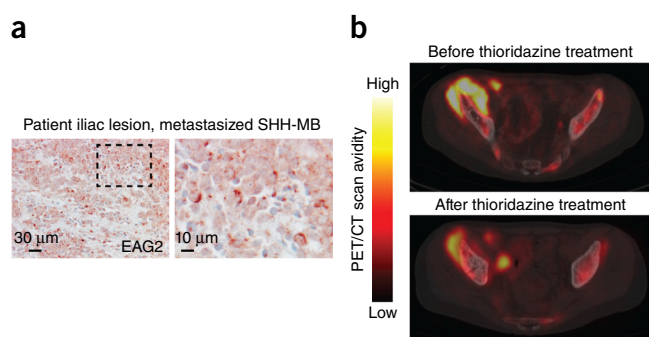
A case report of thioridazine treatment of a patient with metastatic SHH-MB. (a) Patient biopsies at the metastasized iliac lesion revealed prominent EAG2 expression. (b) PET-CT scans before and after thioridazine treatment showed reduction of tumor volume and FDG avidity.
